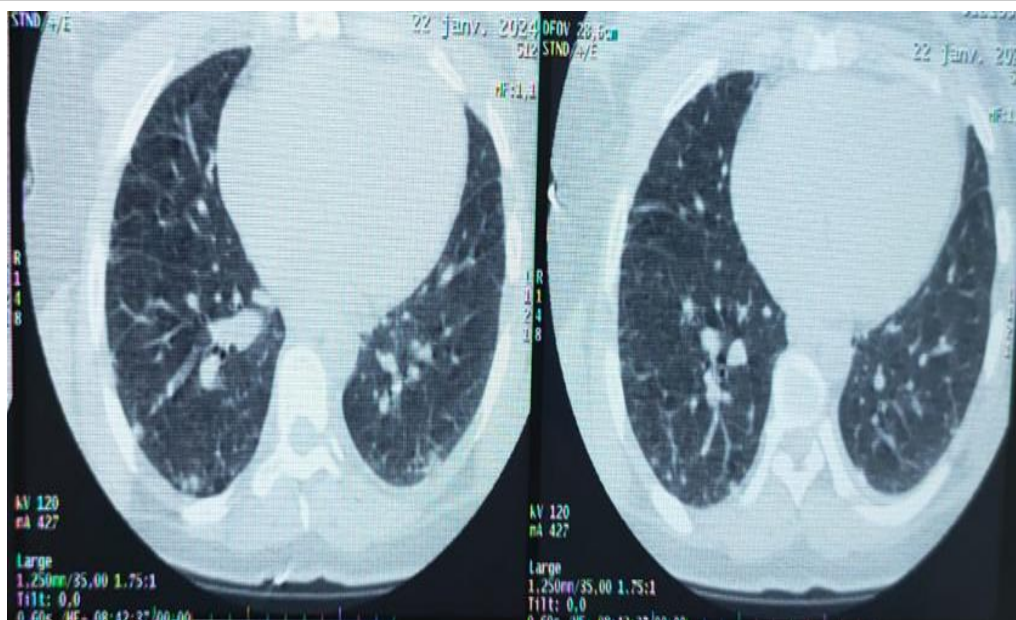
Second CT scan showing the appearance of multiple bilateral nodules pulmonary nodules The largest ones are located in the right apical area and measure 13*22mm , and the left postero-basal area , measuring 28*30 mm
